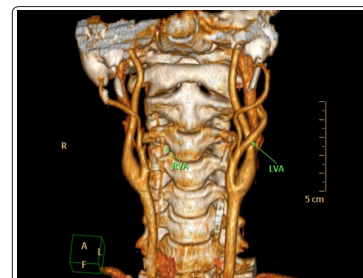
CTA image of left VA traveling outside transverse foramina
